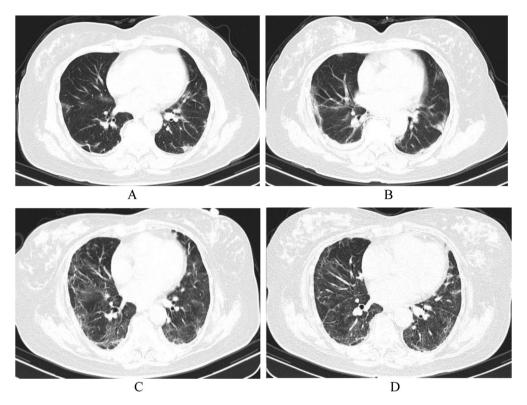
A 60-year-old female had a fever for 2 days. A, CT scan examination was conducted on January 25, 2020. Numerous small pieces of real and rope shadows were observed under the bilateral lung pleural membrane; B, on day 3, a follow-up CT scan examination showed that the area and density of lesions increased; C, after 28 days, the CT scan examination showed that the lung inflammation was slightly absorbed but had extensive fibrosis; D, after 35 days, the CT scan showed that the lesions were slightly absorbed.
